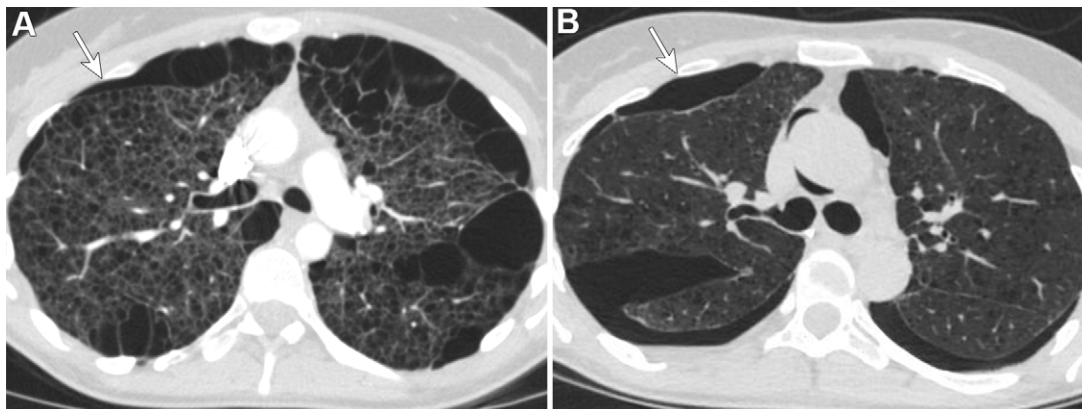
Images in a 32-year-old woman with lymphangioliomyomatosis recurrence. (A) Axial CT image shows multiple small thin-walled cysts and larger subpleural bulla in a pretransplant patient with lymphangioliomyomatosis. There is a small right pneumothorax (arrow). (B) Axial CT image obtained 7 years after bilateral lung transplantation shows multiple small bilateral thin-walled cysts and trace right pneumothorax (arrow) compatible with lymphangioliomyomatosis recurrence. There is also small pneumomediastinum.
